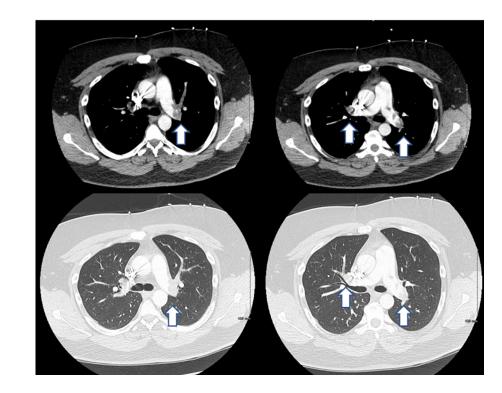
CT pulmonary arteriography showing a large bilateral pulmonary embolism (white arrows).
